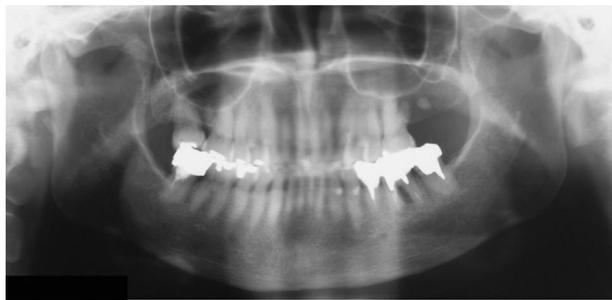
Dental panoramic radiographs of a 57-year-old female patient who had a severely eroded cortex.
